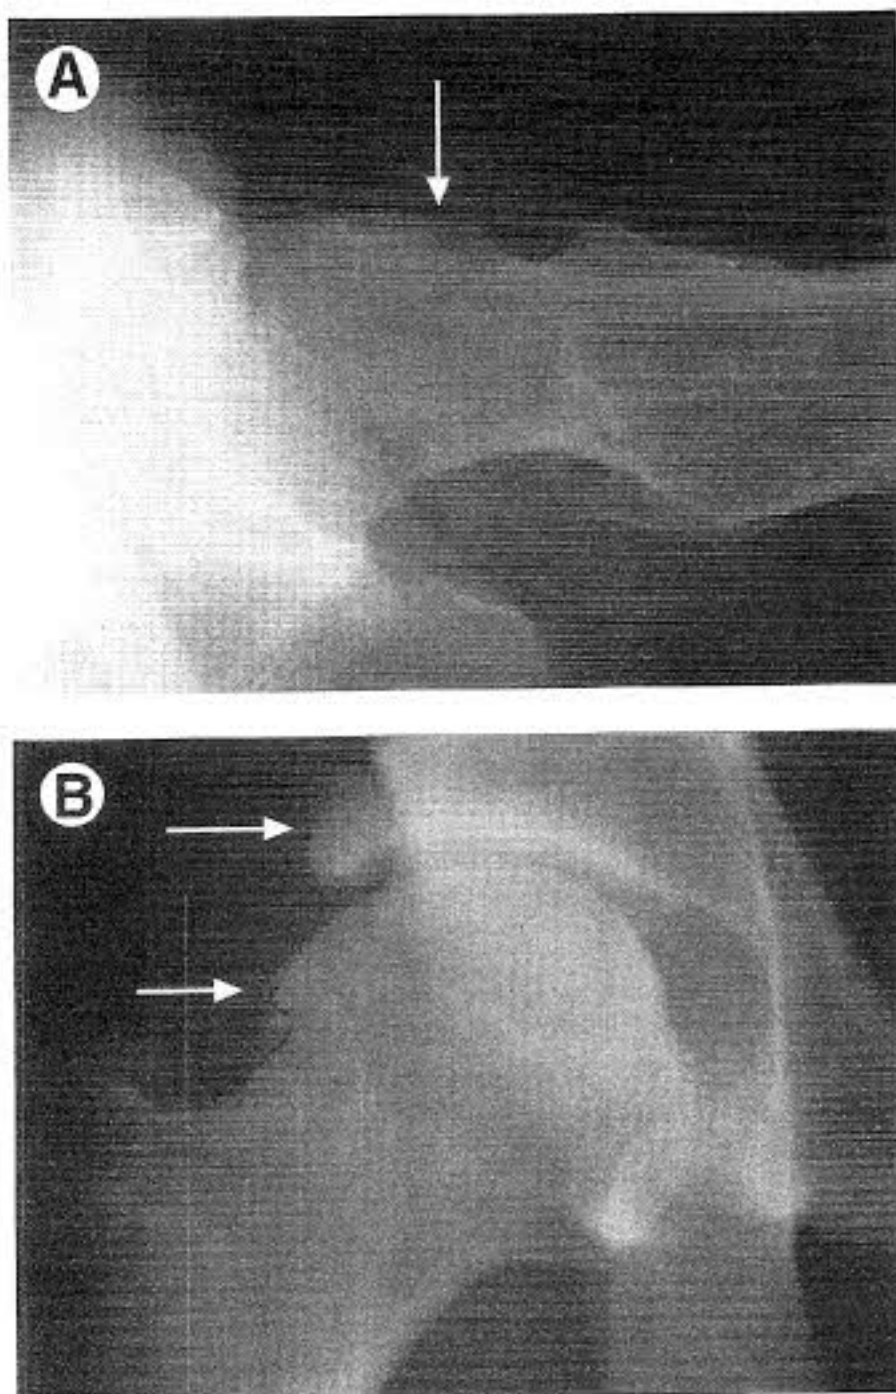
(A) Left hip radiograph in young girl with cam type impingement. Out of round bump on the head overloads the acetabular cartilage as it is rotated into the joint (arrow). (B) Right hip radiograph in a young man with pincer type impingement. Shortened head neck offset abuts the rim of the acetabulum (lower arrow), eventually causing ossification of the labrum which then looks similar to a shear type fracture (upper arrow).
